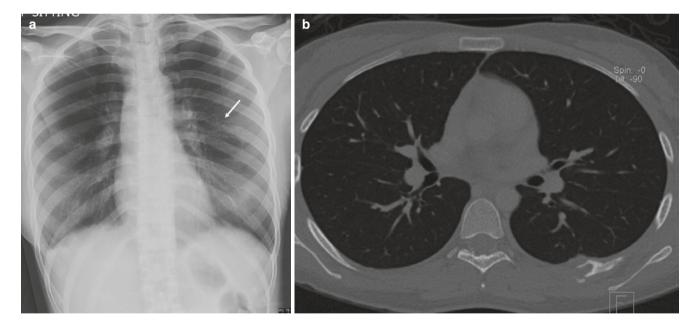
Langerhans cell histiocytosis in a young man. (a) Frontal chest radiograph shows a lytic lesion in the left seventh rib (arrow). (b) Axial CT image and (c) whole body bone scan images demonstrate the solitary lytic rib lesion
